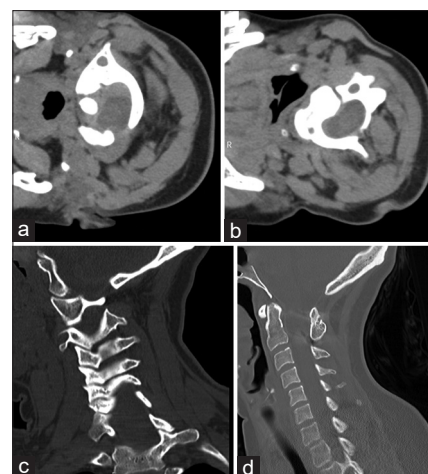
Case 1 imaging - Atlantoaxial instability. (a-c) Preoperative cervical rotational CT turned to the right with C1 axial view. (a) C2 axial view (b) and sagittal view. (c) Demonstrating 45° rotation of C1 on C2. (d) 19-months postoperative sagittal cervical CT demonstrating expected postoperative changes of a C1-2 posterior cervical fusion. CT: Computed tomography
